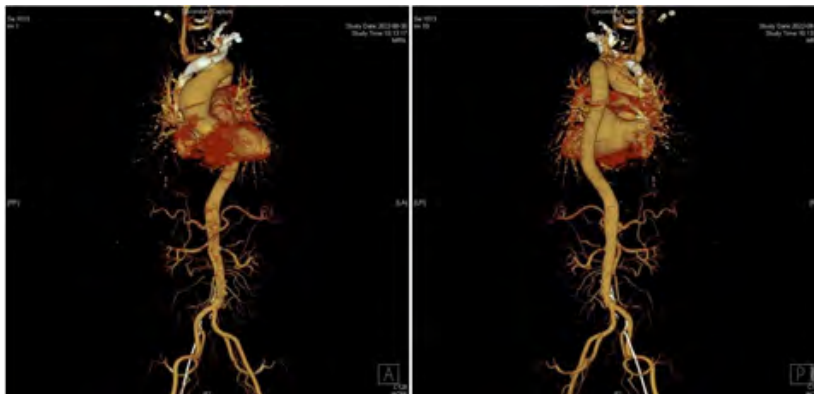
CTA findings showing moderate stenosis of the lumen at the beginning of the abdominal trunk, with possible bacteriophage involvement and visible penetrating ulcers.
